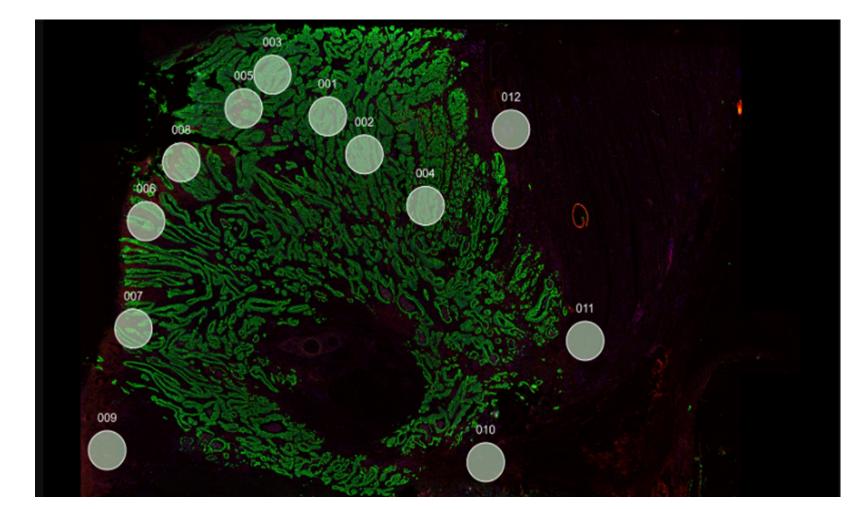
ROI selection for GeoMx CTA testing. A representative DSP image showing ROI selection using PanCK and CD45 in a CRC FFPE sample.
